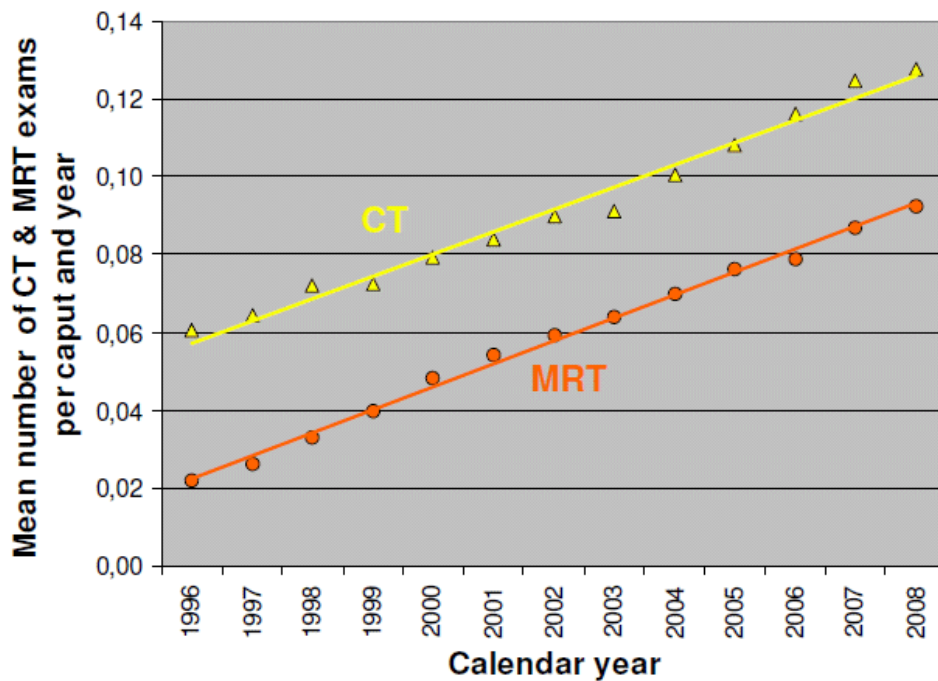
3 – Mean number of CT exams per caput and per year, as a function of time in Germany, for the period 1996-2008. Reproduced from (4).
